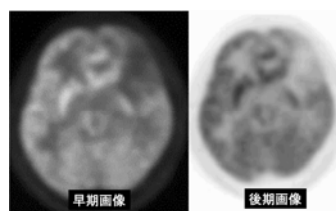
FDG-PET, almost negative study.
